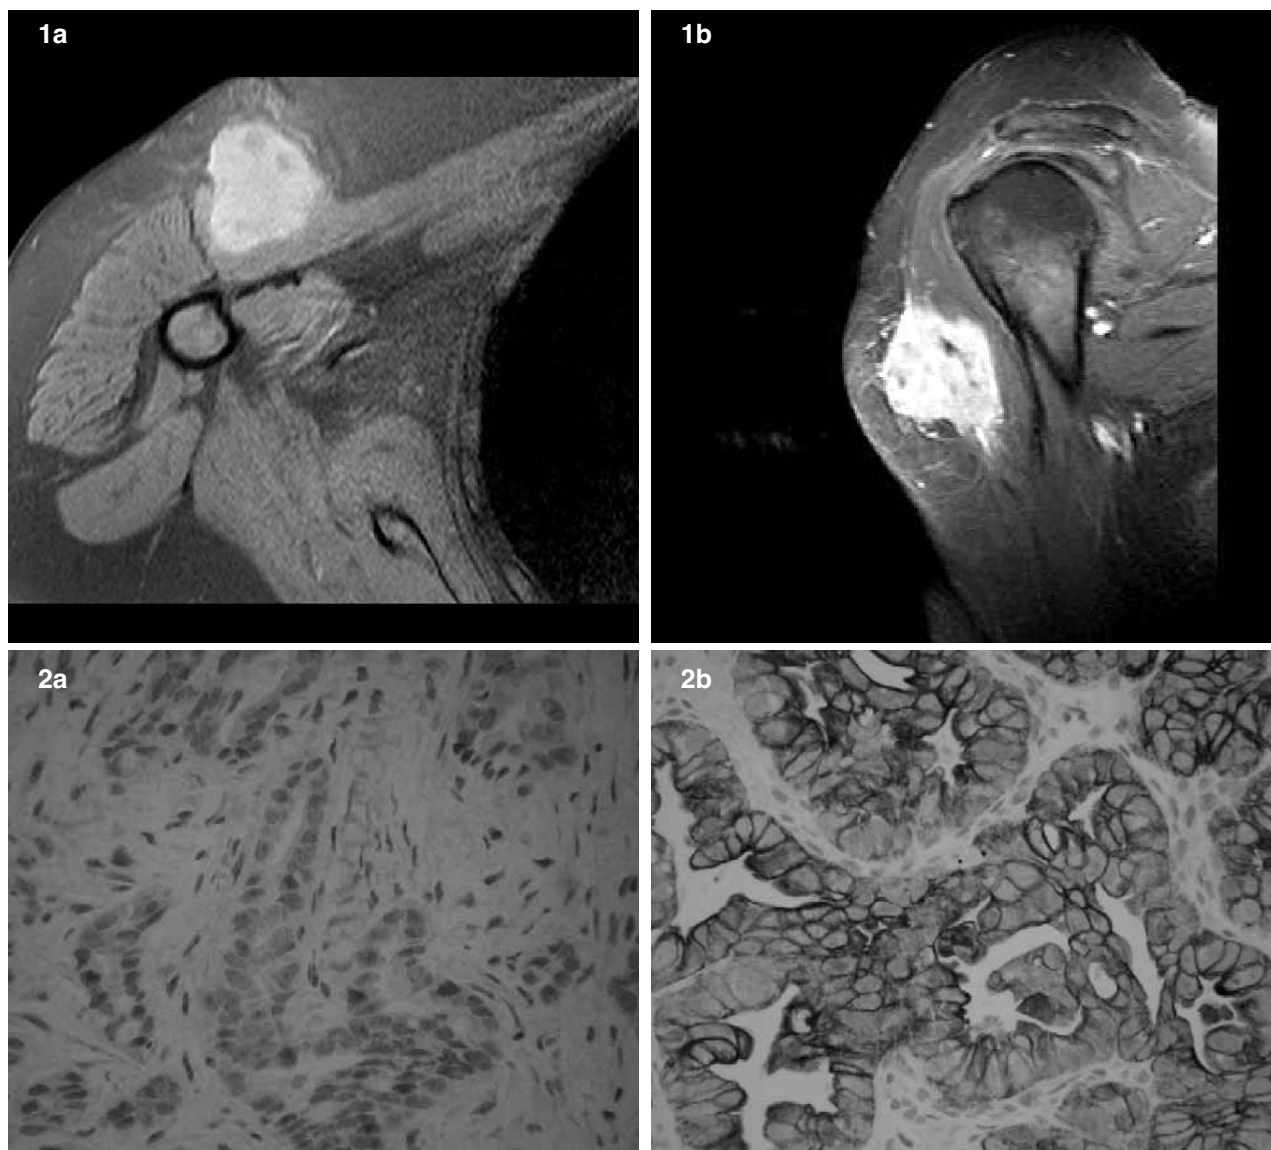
MRI of the deltoid muscle mass: sagittal section (1a) and cross section (1b).
